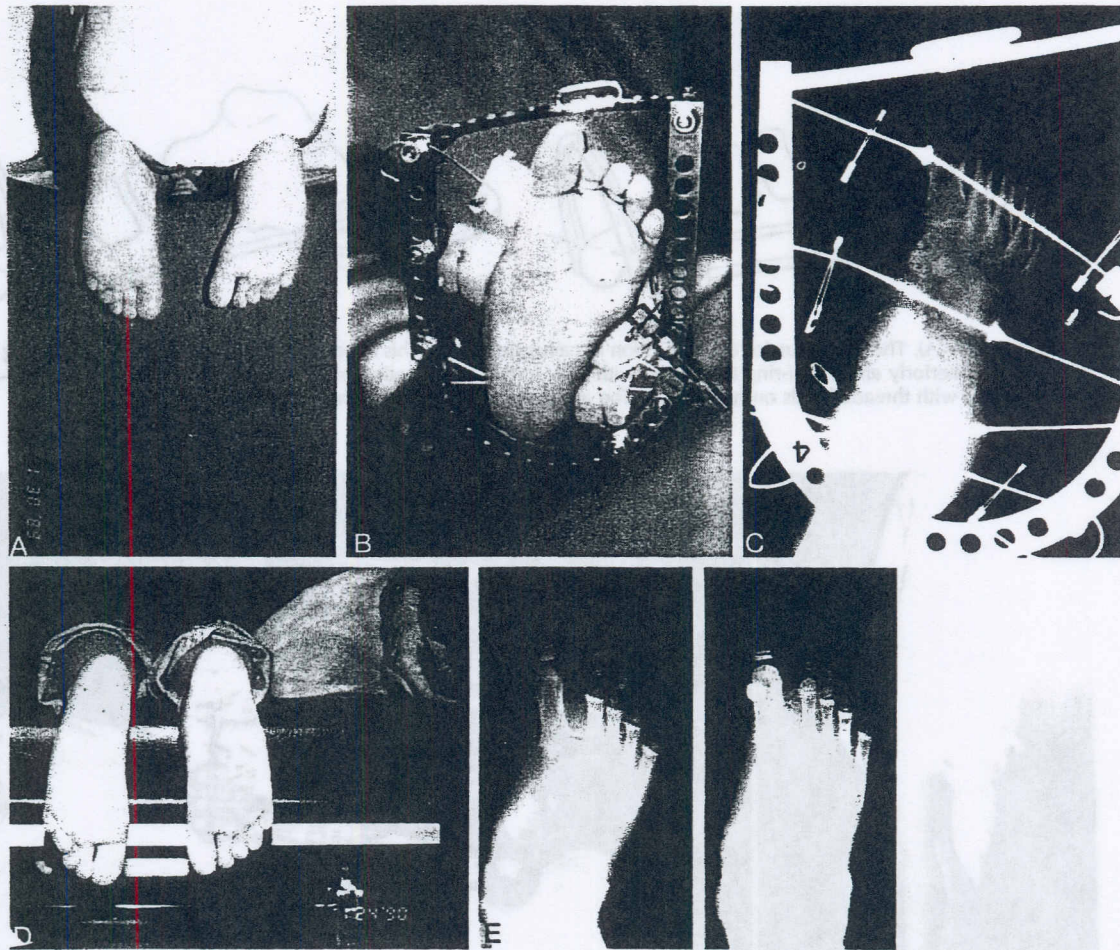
(A), A 4-year-old boy with a persistent metatarsus adductus and a skewfoot despite previous casting. (B), The foot is shown in the apparatus during treatment. (C), The radiograph at the end of treatment showing overcorrection. (D), The clinical appearance of the foot at 1-year follow-up. (E), The standing radiograph of the foot at the end of treatment (right) compared with before. (Courtesy of Dror Paley, M.D.)
